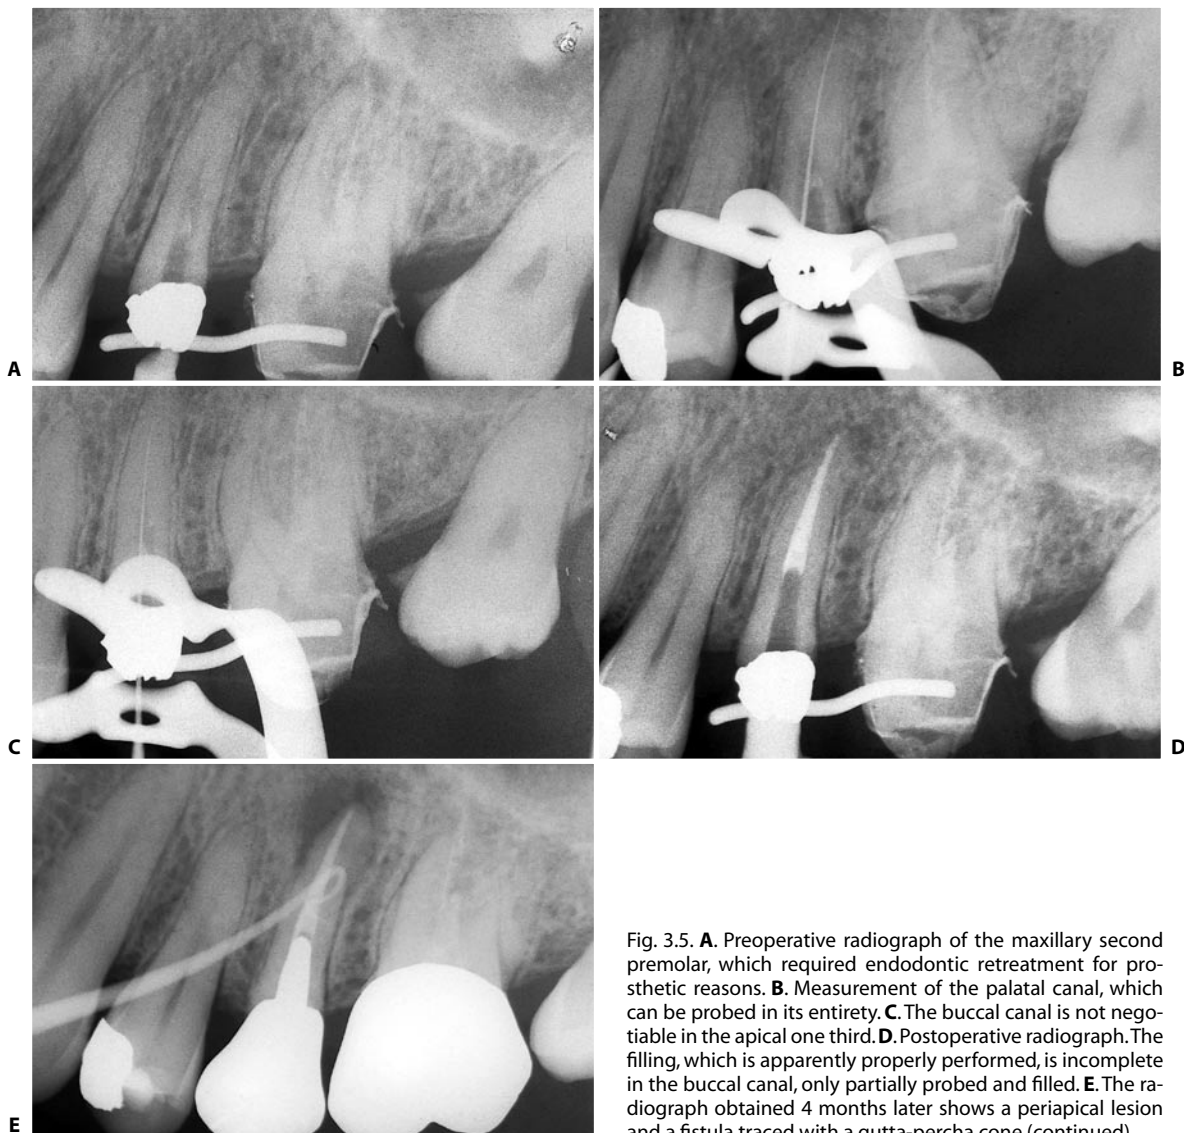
A. Preoperative radiograph of the maxillary second premolar, which required endodontic retreatment for prosthetic reasons. B. Measurement of the palatal canal, which can be probed in its entirety. C. The buccal canal is not negotiable in the apical one third. D. Postoperative radiograph. The filling, which is apparently properly performed, is incomplete in the buccal canal, only partially probed and filled. E. The radiograph obtained 4 months later shows a periapical lesion and a fistula traced with a gutta-percha cone (continued).
